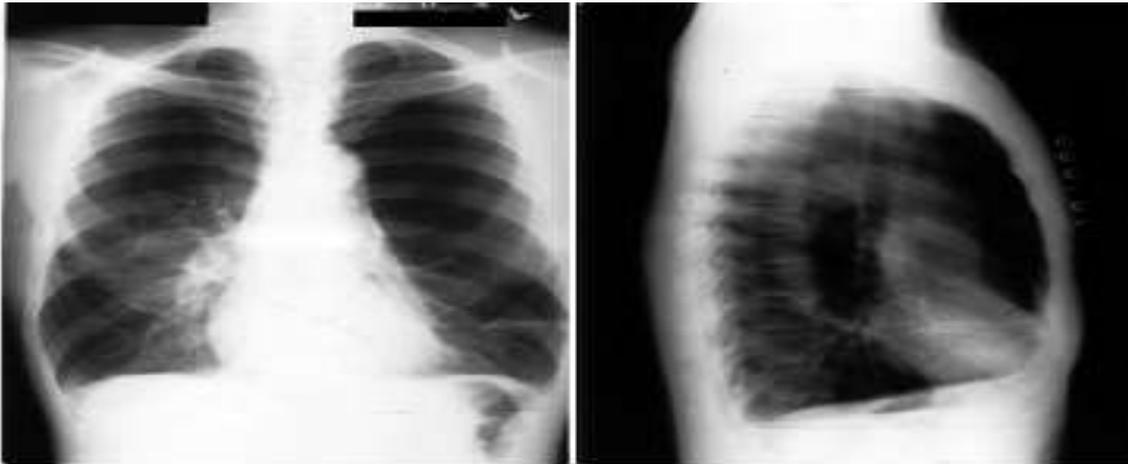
Frontal (A) and lateral (B) chest radiographs of a case of bullous emphysema. There is pulmonary vascular scarcity, dilation of the right interlobar artery on the face
